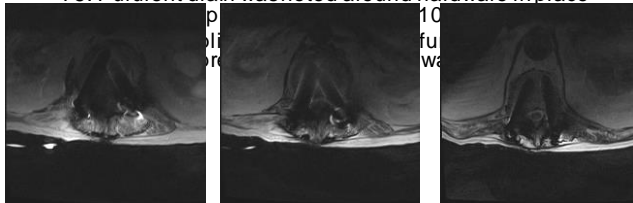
Axial images on MRI Thoracic spine T2 showing limitations of MRI in evaluating spinal and paraspinal pathology due to artifacts created by spinal hardware.
